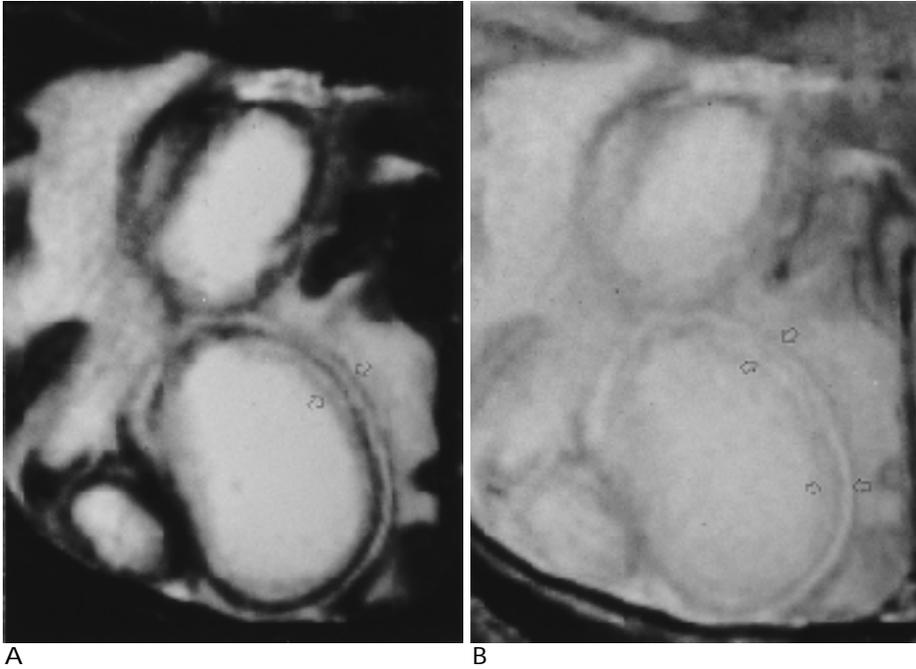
Multiple layers within the lobulating abscess wall at right parieto-occipital lobe in a 38-year-old man. A, B. T2-weighted(a), and proton-density weighted(b) axial images show alternating multiple layers of the abscess wall(open arrow).
